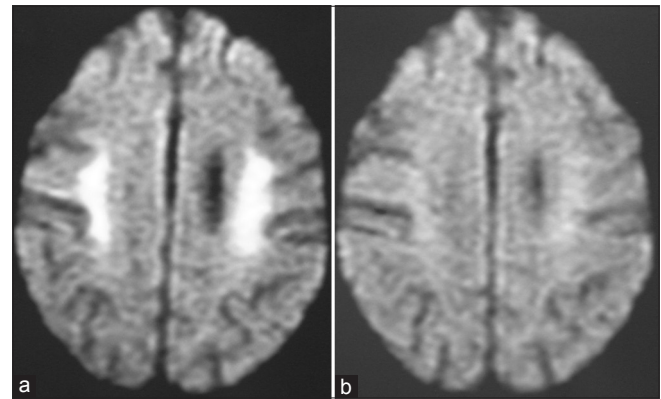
(a) High signal intensity was detected in bilateral frontal white matter on diffusion-weighted MRI (b) The lesion had disappeared on MRI on the next day with the recovery from hypoglycemia
